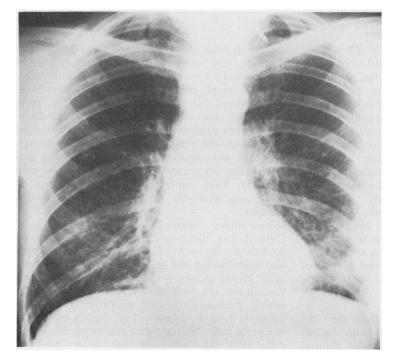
Postero-anterior radiograph two months later after administration of prednisone and cyclophosphamide.
